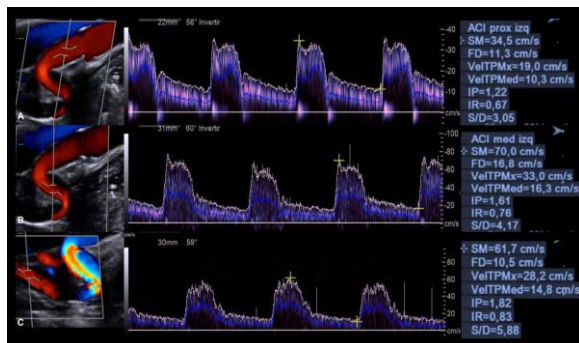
52-years old women with tinnitus. ICA with color and pulsed Doppler application. Evaluation of the ICA before the first angulation with a PS velocity of 34.5 cm / s, After the first angulation with a PS velocity of 70 cm / s. After second angulation with a PS velocity of 61.7 cm / s. After the first angulation, a doubling of the initial velocity is observed, from 34.5 cm / s to 70cm / s, still within normal parameters.
